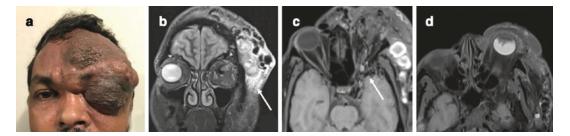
CAMS 2. 35 year old male with large left forehead and eyelid swelling for many years. There is history of episodes of bleeding from the lesion and proptosis and redness of the left eye for 6 months. (a) Clinical photograph. (b) MRI T2WI showing the superficial scalp and forehead AVM. (c) Signal voids are seen within the left greater wing of sphenoid suggestive of intraosseous AVM (Arrow). (d) Vitreous haemorrhage. (e) Prominent cortical vein in the left frontal region. (f) Right ECA angiogram shows frontal cortical direct leptomeningeal Dural arteriovenous fistula on the left side. The supply is through middle meningeal artery crossing the midline and supplying the fistula in the left frontal region (g, h) Left ECA
